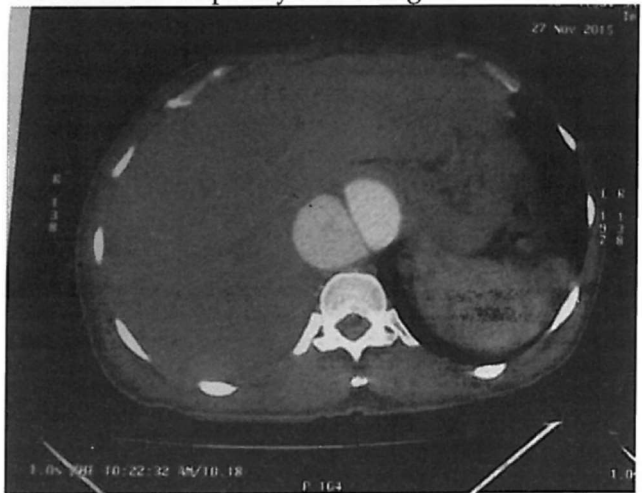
Contrast-enhanced axial CT image demonstrates an intimal flap separating the two channels in the descending aorta diagnostic of a Stanford type A dissection.
